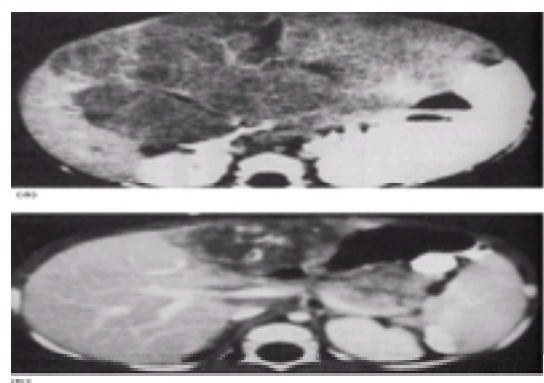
(a) CT scan of an 8-month-old female who presented with a massive hepatoblastoma. Only the margin of the right lobe appears normal. (b) Dramatic response of the tumor shown on the follow-up scan 4 months later allowed successful resection of the tumor and the child remains disease free 10 years later.
